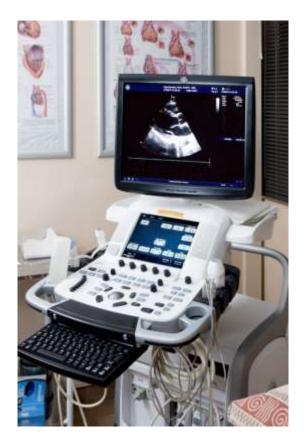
A photo taken of the General Electric Vivid E9 device in the HART Research and Training Lab for echocardiography data
